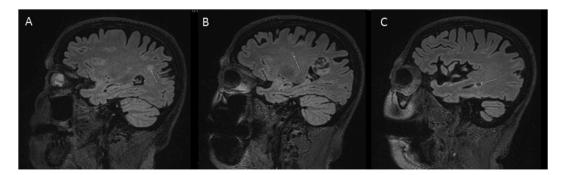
Sagittal T2-weighted gadolinium enhanced MRI (magnetic resonance imaging) showing three suspicious-looking nodular lesions localized in left temporal lobe (A), left frontal lobe (B) and right occipital lobe (C). Polycystic left parietal tumor is also evident in section B.
